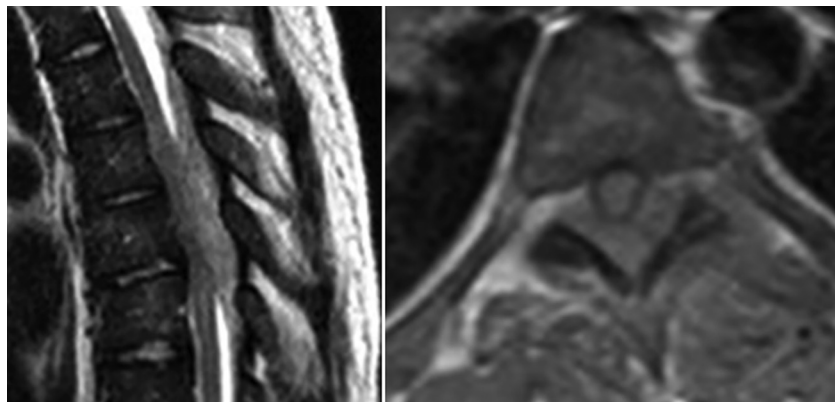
Preoperative T₂-weighted sagittal (left) and axial (right) magnetic resonance images of posterior epidural mass causing spinal cord compression.
